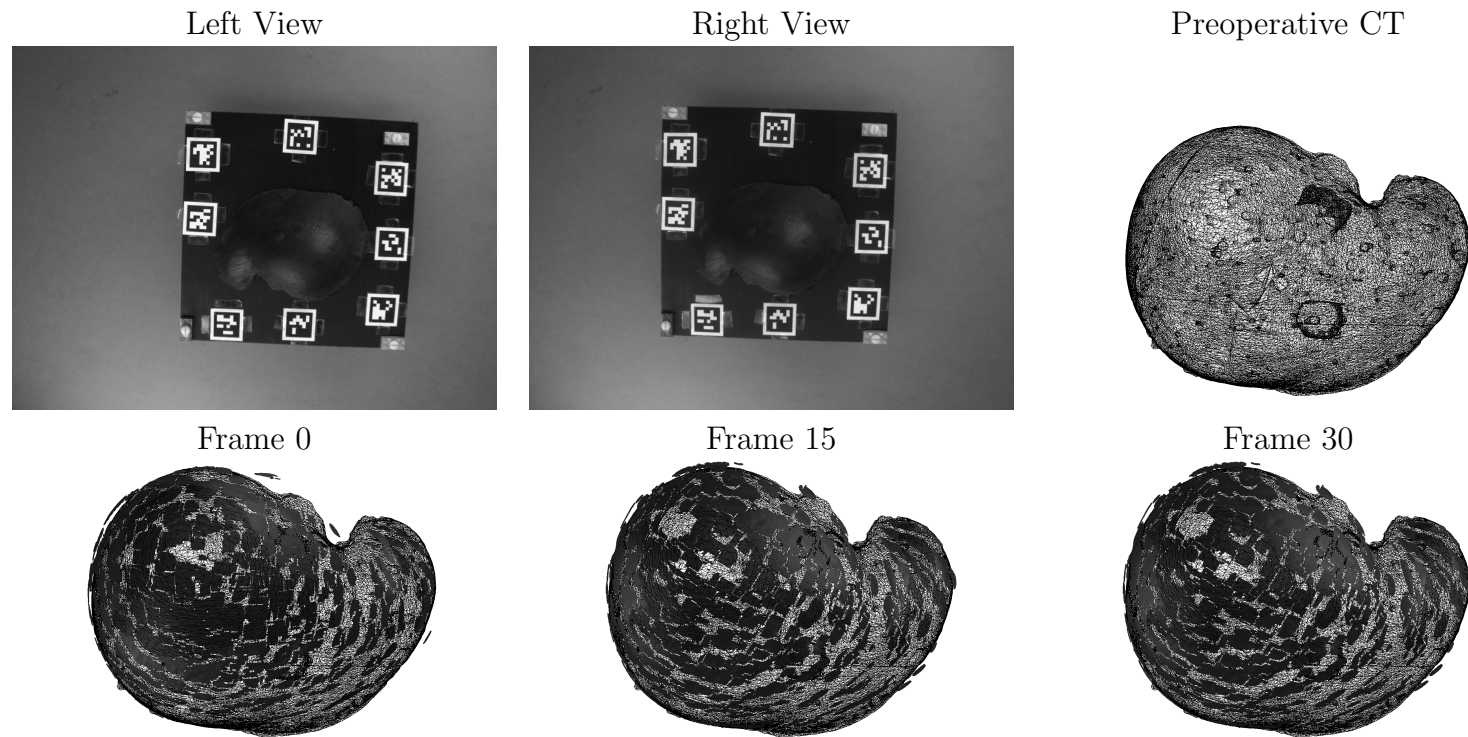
Qualitative Surface Registration Error (SRE) Results - Rotation-Only. The left and right (non-rectified) views from the stereo camera are shown at the initial frame (frame 0). The preoperative *CT* scan is shown in a top-down view. The recovered stereo reconstructions (shown in darkest grey), registered to the preoperative *CT* scan, are shown at frames 0, 15, and 30.
